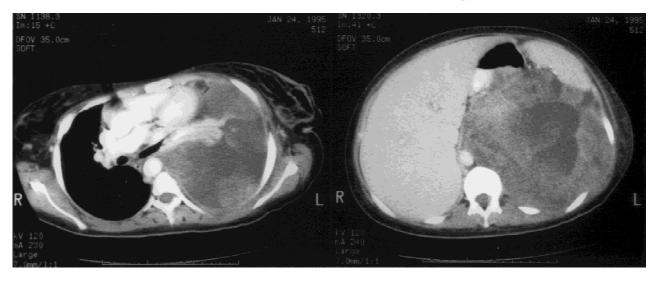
CT scans of the chest (left) and abdomen (right) show a mass measuring 33×18 cm occupying the left side of the abdomen and extending to the left hemithorax. The mass displaces abdominal contents and heart to the right side.
